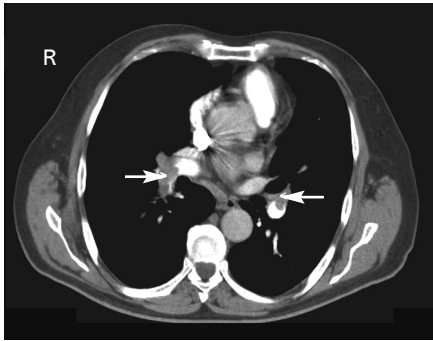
Computed tomography pulmonary angiogram. Thrombus is seen in both main pulmonary arteries.
